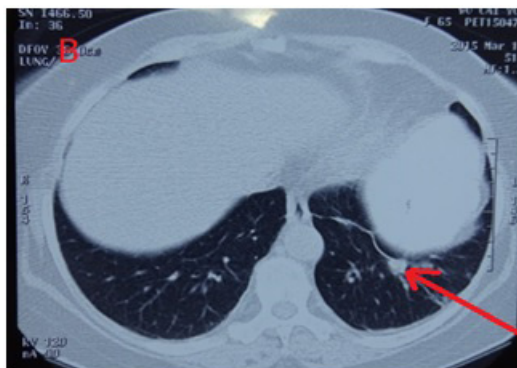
This patient already had a metastasis at left lung before any treatment (Arrow show a small mass and clinical diagnoses as a metastasis without PET/CT and pathological proved).
